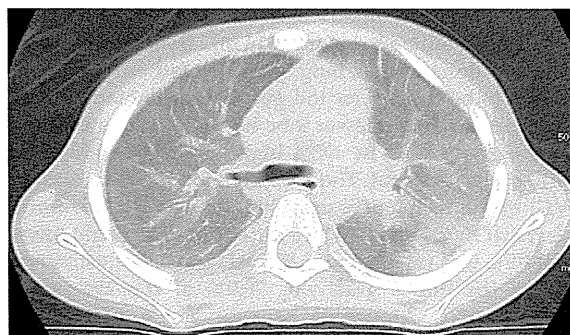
Chest computed tomography of a 6-year-old girl with pulmonary venoocclusive disease before referral to our hospital. Smooth septal thickening and diffuse or mosaic ground-glass opacities were recognized. Areas of alveolar consolidation were also seen in the bilateral posterior lower lobes.
